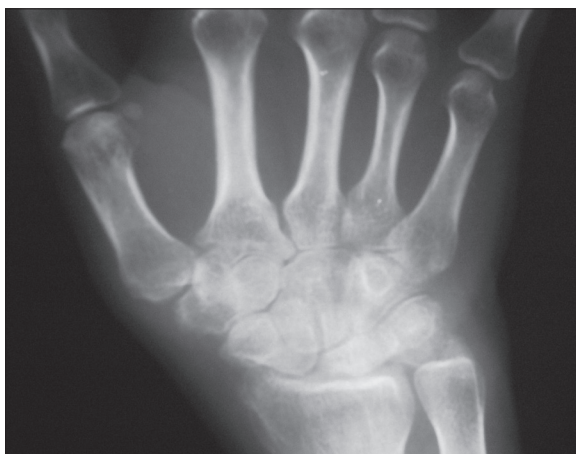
36-year-old female with a 3 month history of inflammation of the wrist. X-ray of the wrist. Periarticular osteoporosis. Soft tissue thickenings.
